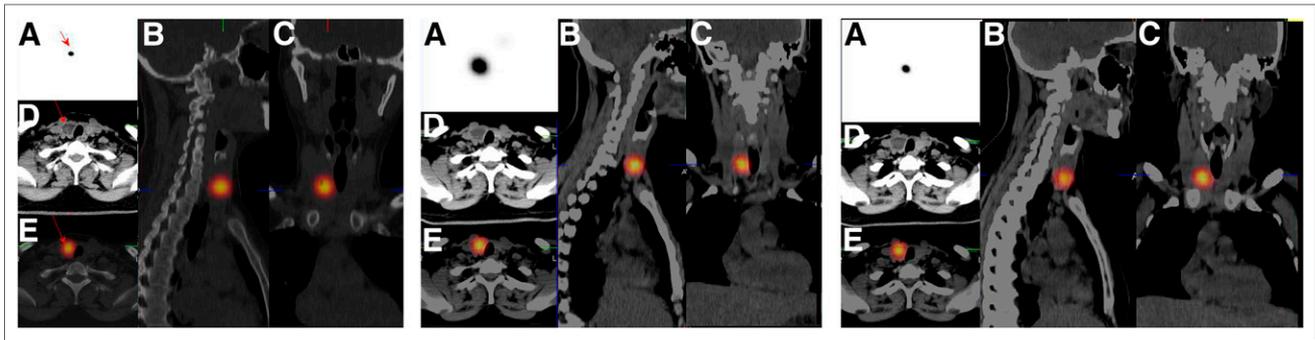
Imaging at 1 h (left panel), 24 h (middle panel), and 1 wk (right panel) after radioactivity injection. Each panel shows SPECT (A), sagittal fusion (B), coronal fusion (C), axial CT (D), and axial fusion (E) images. Only intranodular activity is seen.
